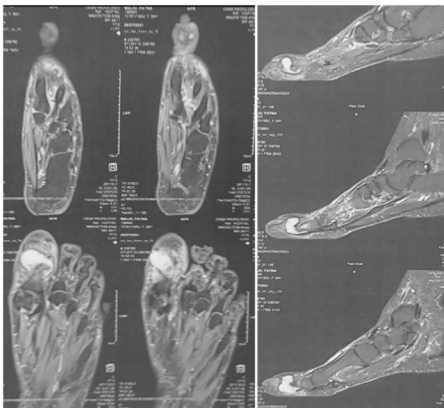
MRI of the right forefoot, collection at the first PPI joint in T2 hypersignal.
